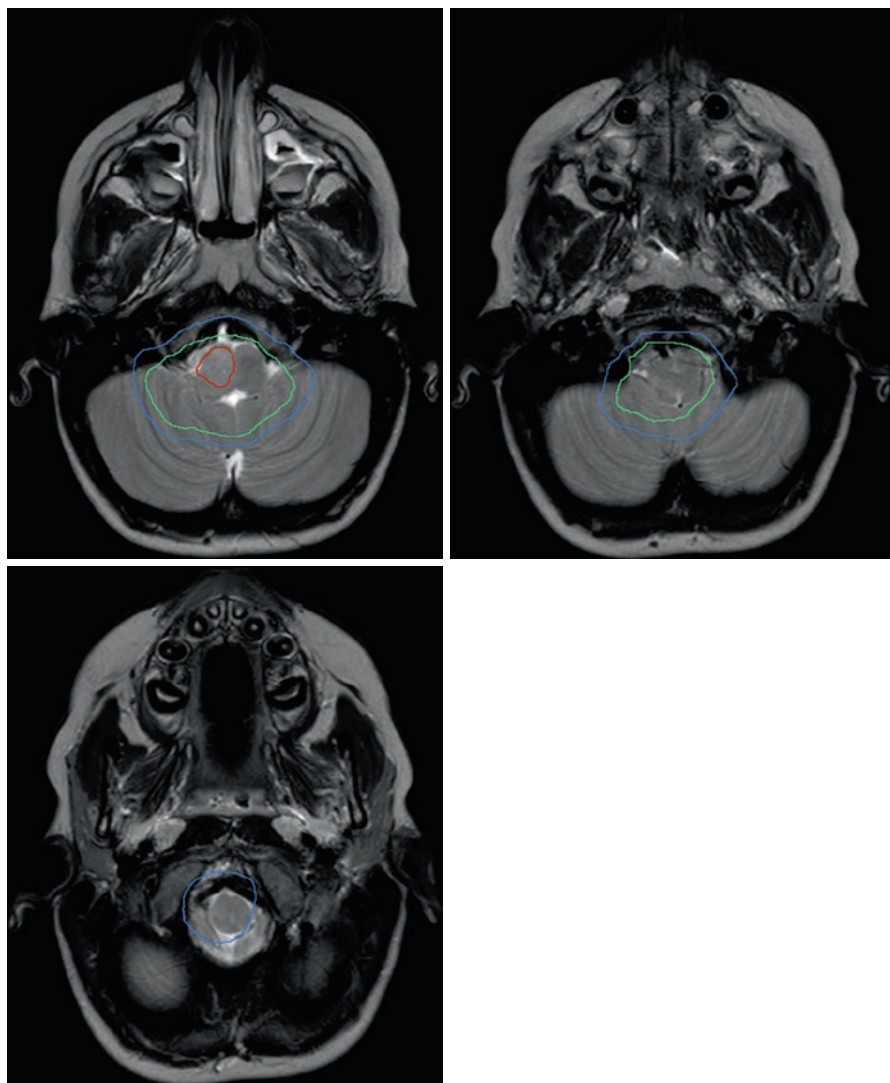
Diffuse intrinsic pontine glioma case. Axial T2-weighted MRI slices of the head of a patient with a DIPG are shown. Red = GTV which includes the T2/FLAIR abnormality and any abnormal enhancement. Green = CTV (GTV + 1 cm). Blue = PTV (CTV + 3 mm). Purple = left cochlea. Teal = right cochlea
